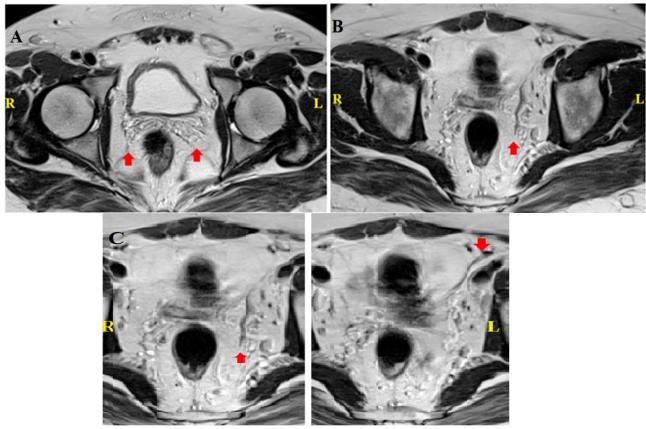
Atrophic seminal vesicles and absence of vas deferens on the right. (A) Axial T2-TSE weighted MRI images show abnormal SVs with low T2 signal intensity. The SVs (red arrow) were diffusely atrophied with low T2 signal, consistent with radiation atrophy or dysgenesis. (B) Axial T2-Blade weighted MRI images show the absence of the right-side vas deferens at the intraabdominal portion. The left side vas deferens is pointed with a red arrow; (C) it could be seen through different MRI slices.
